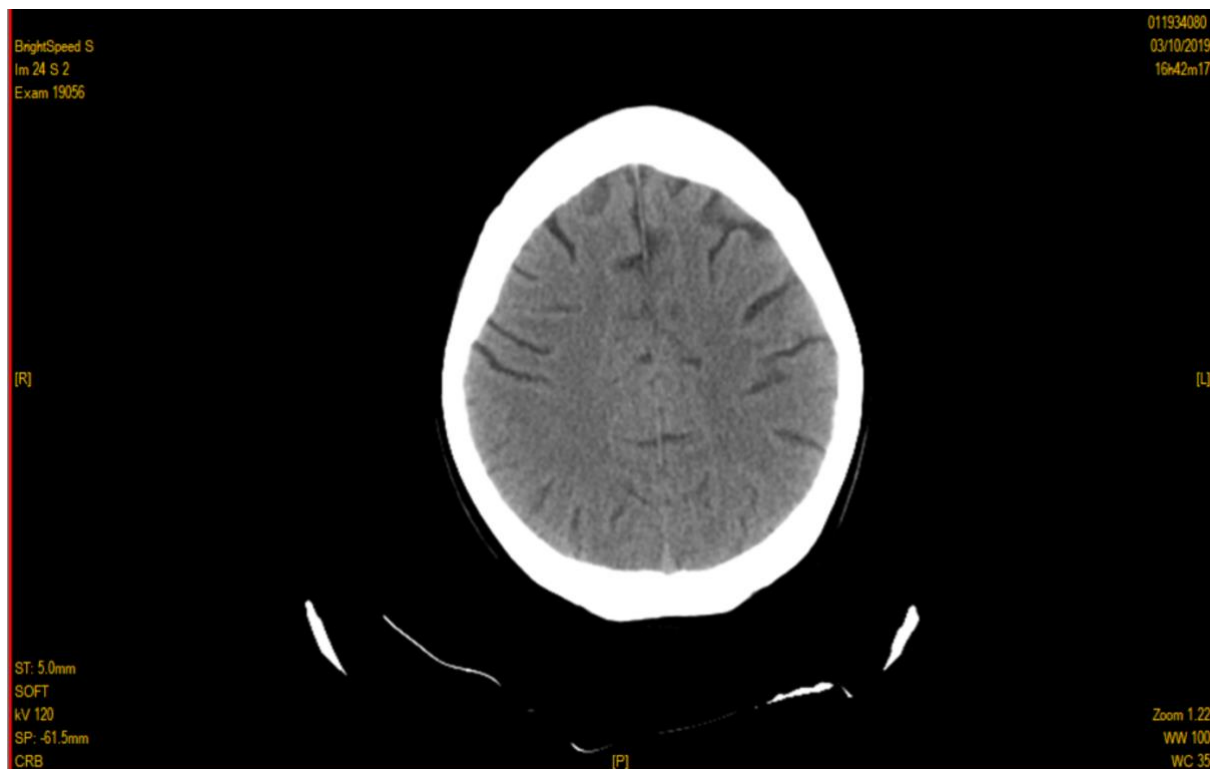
Normal brain CT scan found in one of study patients
